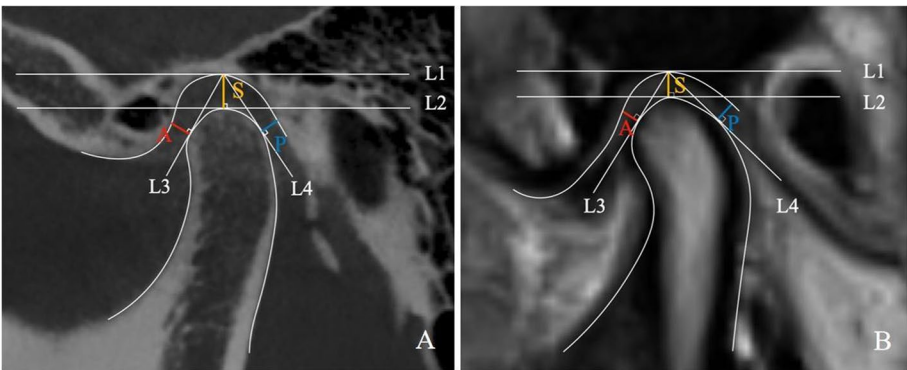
Kamelchuk's method for measuring CBCT (A) and MRI (B) articular clearance
